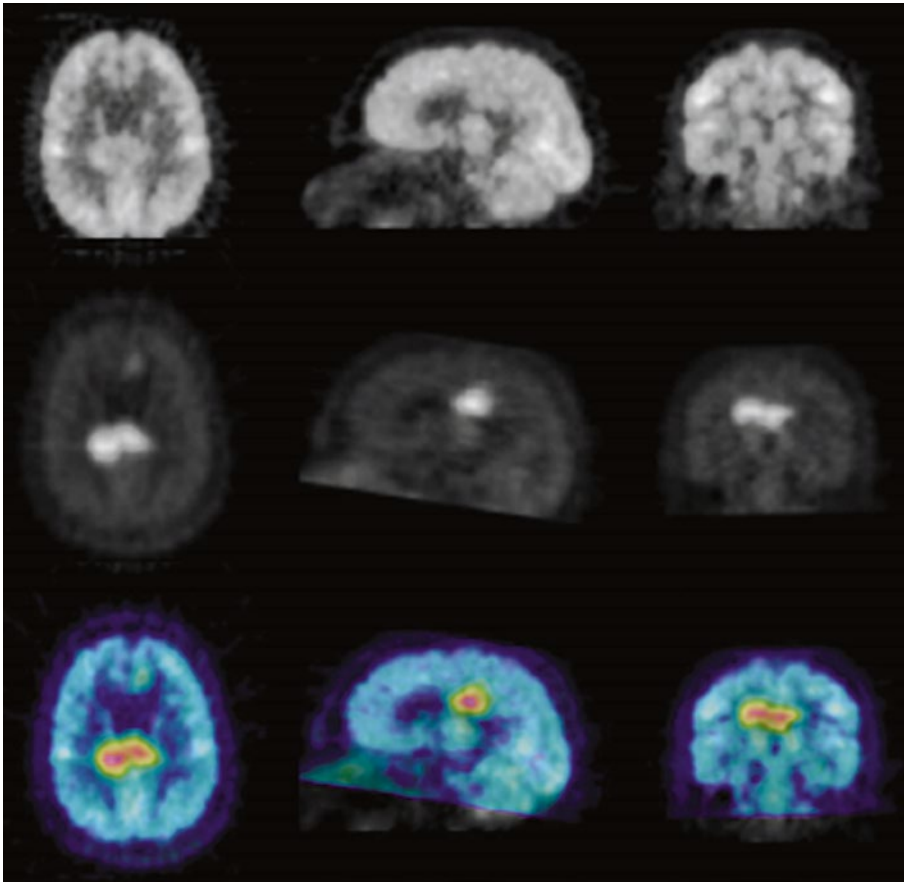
Brain tumor: carbon-11 (^{11}C) methionine versus ^{18}F -FDG. *Top:* ^{18}F -FDG brain PET that faintly outlines tumor uptake. Tracer within the normal brain matter tends to make diagnosis of active tumor difficult. *Center:* ^{11}C -methionine brain PET shows the region of tumor
